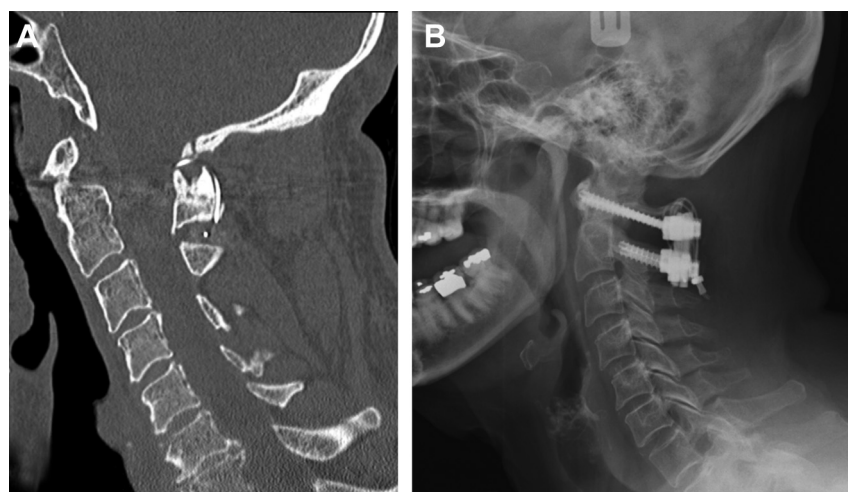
(A) Midsagittal reconstructed computed tomography scan obtained at 6 months demonstrating bridging bone. (B) Lateral cervical spine radiograph obtained at 6 months demonstrating the cabled allograft construct with no loosening of hardware.
